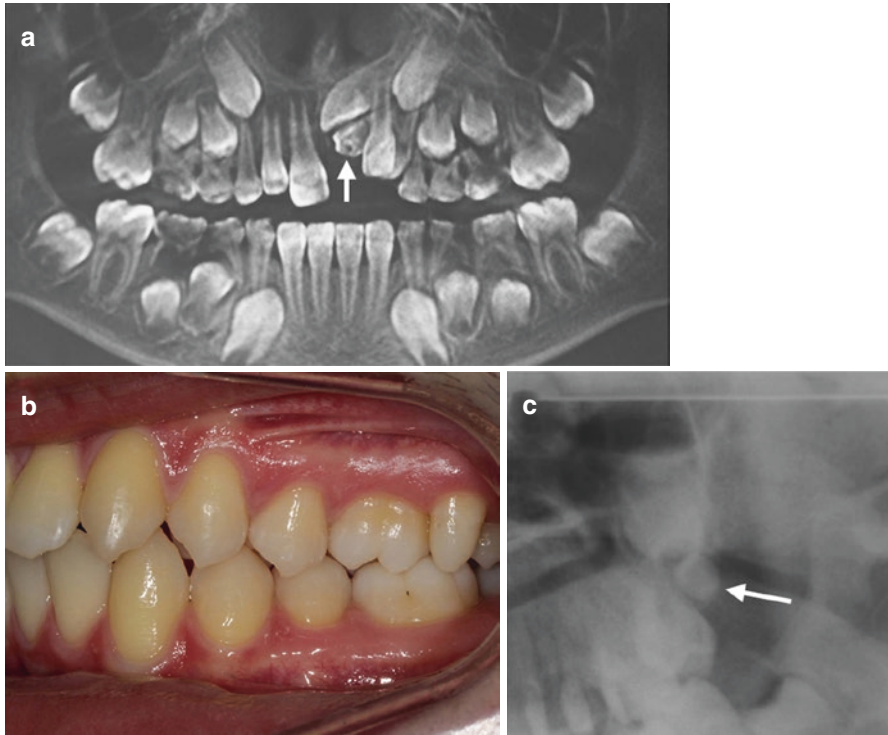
(a) DPT showing a midline supernumerary tooth (tuberculate) (*arrowed*) preventing eruption of the UL1 (see also Fig. 4.4b). (b) Erupted paramolar between the upper left first and second molar. (c) Section of a bimolar radiograph showing a distomolar in the upper left buccal segment (*arrowed*)
